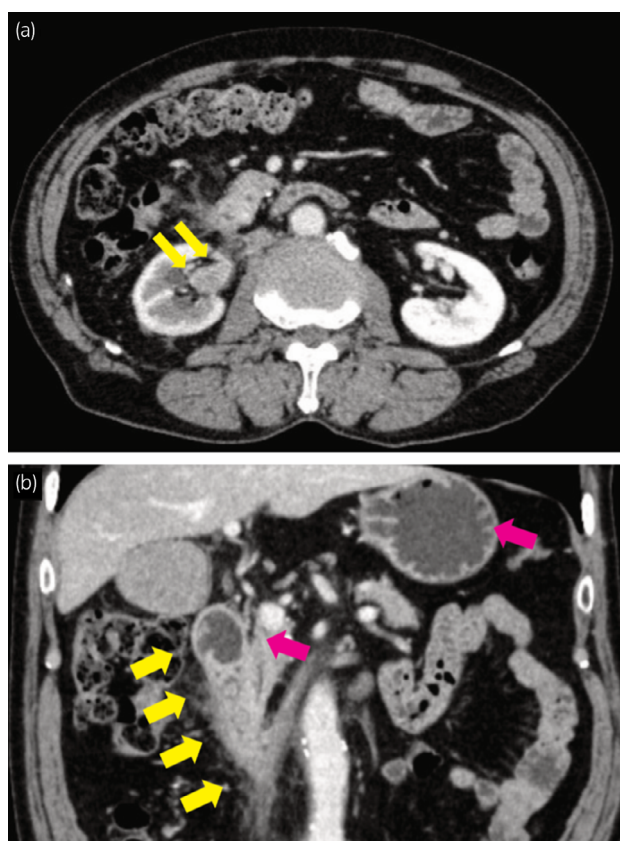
Computed tomography findings of the current case. (a) A soft tissue mass in the right renal pelvis (yellow arrows). (b) Wall thickening of the second portion of the duodenum and suspected inflammation in the para-duodenum (yellow arrows), and dilatation of the stomach and the first portion of the duodenum (pink arrows).
